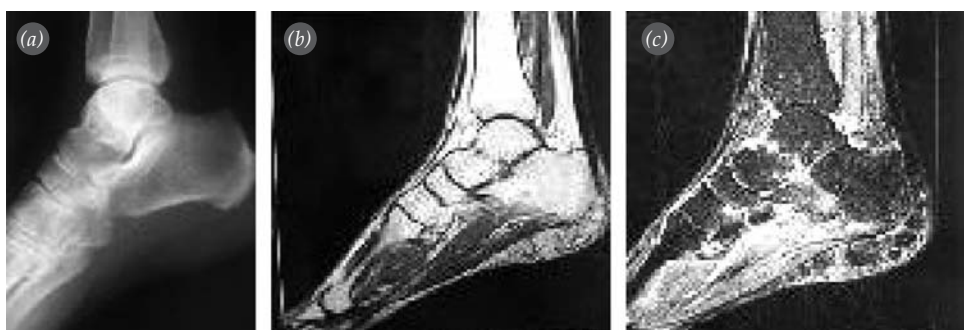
(a) Initial lateral radiograph, (b) sagittal T1-weighted MR imaging, and (c) sagittal T2-weighted MR imaging of missed talar neck fractures in ankle distortions.
